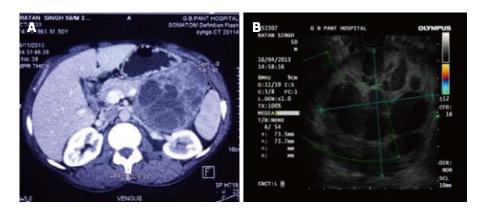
Contrast enhanced computed tomography and endoscopic ultrasound for pancreas. A: Contrast enhanced computed tomography shows 10.8 cm × 8.1 cm × 9.1 cm solid cystic mass arising from body and tail of the pancreas; B: Endoscopic ultrasound showing a well-encapsulated heteroechoic mass inseparable from tail of pancreas.
